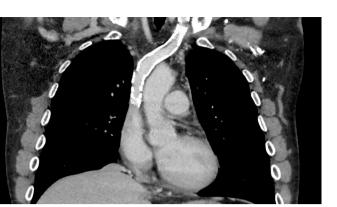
CT-scan of the thorax at initial presentation showing extensive venous stenosis and thrombosis of the caval vein.
